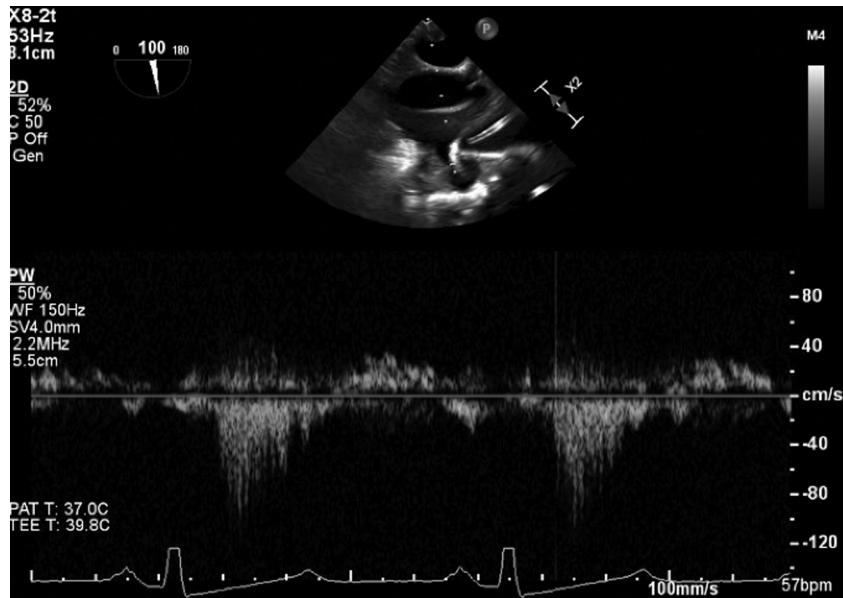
Pulsed-wave Doppler at the neck of the pseudoaneurysm shows the “to-and-fro” waveform representing blood going in and out of the cavity during the cardiac cycle.
